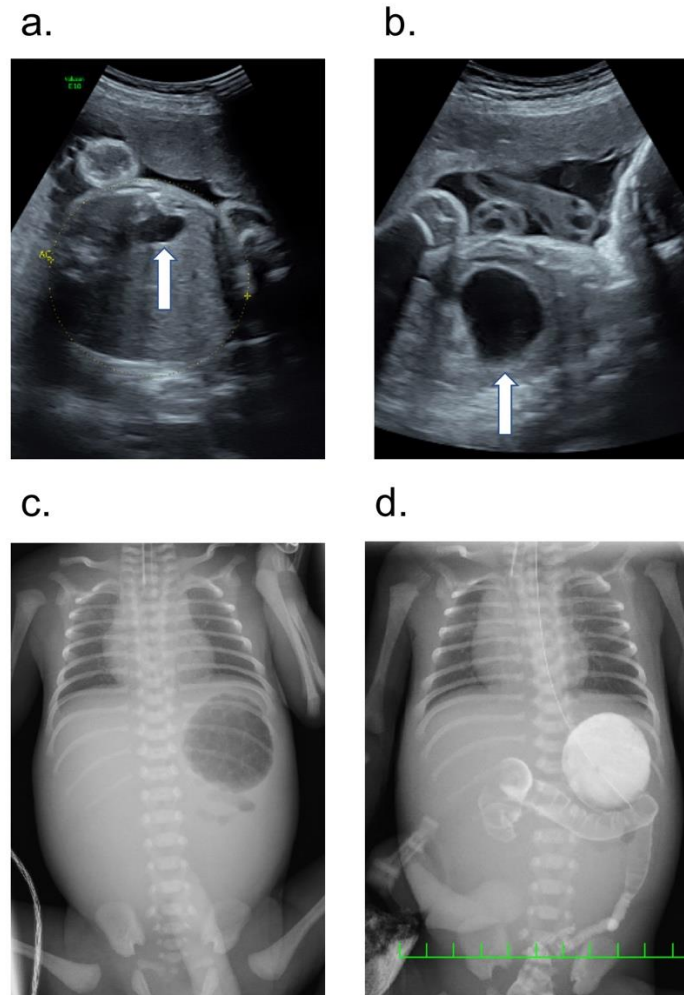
(a) Fetal ultrasonography at 32 weeks, 1 day of gestation without gastric dilatation. (b) Fetal ultrasonography at 33 weeks, 0 days of gestation and (c) an abdominal X-ray at birth and (d) post-contrast study show massive gastric dilatation. The white arrow indicates gastric bubbles.
